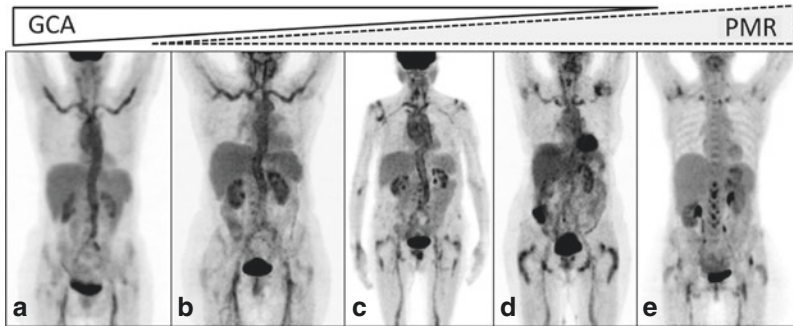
FDG-PET/CT, MIP (maximum intensity projections)-PET scans of torso in patients with GCA and PMR. Cases a and b are typical for GCA and cases d and e are typical for PMR cases, while case c represents a mixture of features. Lesser mixtures of PMR and GCA signs are also seen in cases b and d, with predominance of only a subset of components. This demonstrates that the characteristic signs of GCA and PMR are frequently not clear or exact
